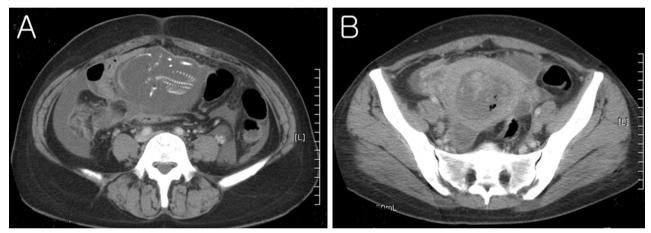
(A) Axial CT image of the abdomen showing fetal tissues surrounded by bowels. (B) Axial CT image of the pelvis showing intrauterine mass with air. Note the absence of a fetus in the uterine cavity.
